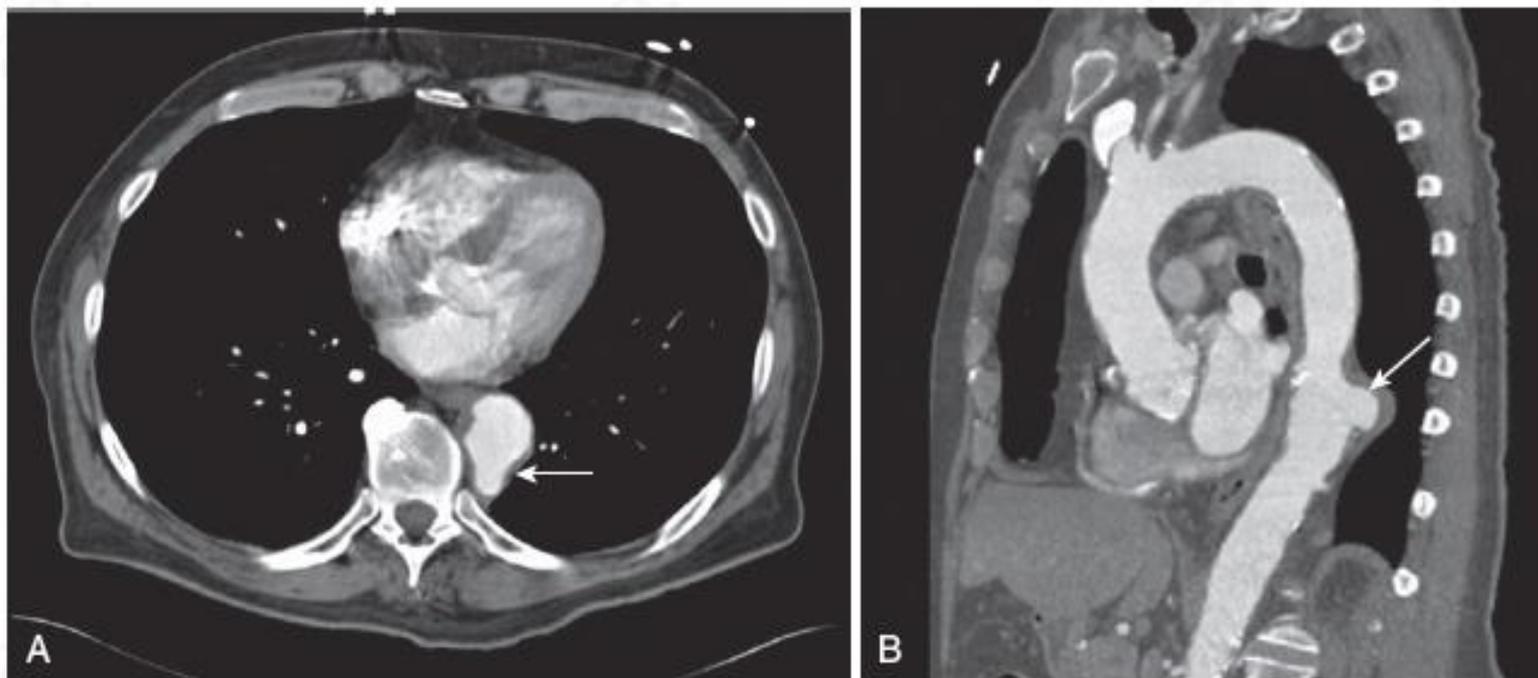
Contrast-enhanced computed tomography scan demonstrating an acute penetrating atherosclerotic aortic ulcer (PAU). A, Axial image demonstrating the typical focal outpouching of the aortic ulcer (*arrow*). B, Sagittal image demonstrating the PAU (*arrow*) with associated intramural hematoma. Symptomatic PAU has an increased risk of aortic rupture and is often amenable to endovascular repair. (From Braverman AC. Aortic dissection. In Levine GN, editor. Color Atlas of Cardiovascular Disease. New Delhi, India: Jaypee Brothers Medical Publishers; 2015, pp 895-903.)
